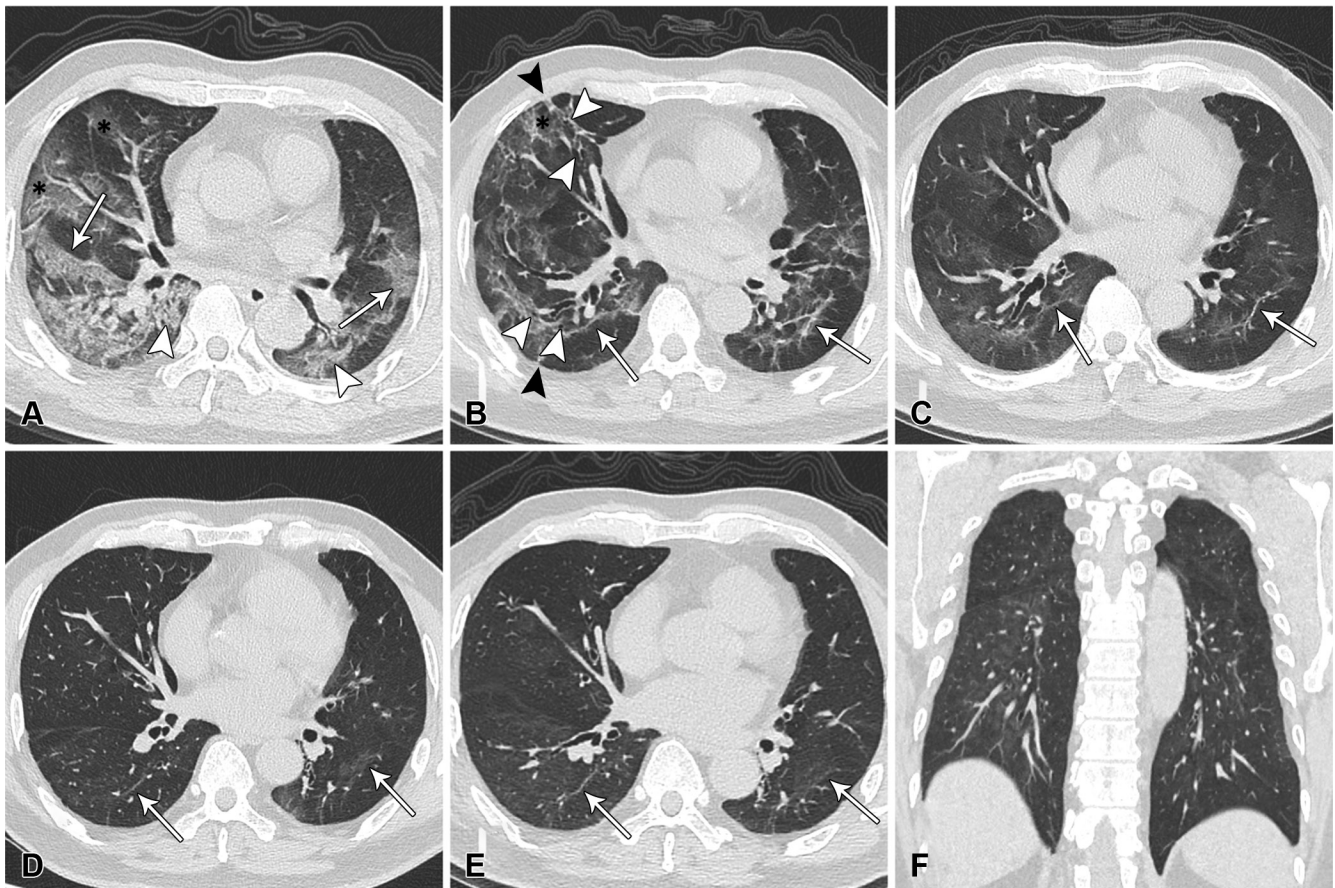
CT scans in 64-year-old man, who progressed to acute respiratory distress syndrome caused by COVID-19, show typical findings over time for participants with residual linear opacities. (A) Eight days after symptom onset, CT scan shows bilaterally diffuse mixed lesions, including ground-glass opacities (GGOs) (*), “crazy paving” appearance (arrows), and consolidation (arrowheads). (B) Fifty-two days after symptom onset, CT scan at discharge shows extensive GGOs and residual linear opacities (arrows), with focal volume loss indicated by displacement of major fissures, adjacent thickening of pleura, bronchial dilation (white arrowheads), parenchymal bands (black arrowheads), and reticular lesions (*). (C) Three months after symptom onset, CT scan shows continued resolution, with only residual GGOs and residual linear opacities (arrows) in bilateral lungs. (D) Seven months after symptom onset, bilateral GGOs and residual linear opacities (arrows) continue to be partially absorbed. Twelve months after symptom onset, (E) CT scan shows stable residual GGOs and residual linear opacities (arrows) compared with (F) previous CT scan, which shows them predominantly distributed in dorsal regions. All images have same window level of -600 HU and window width of 1600 HU.
